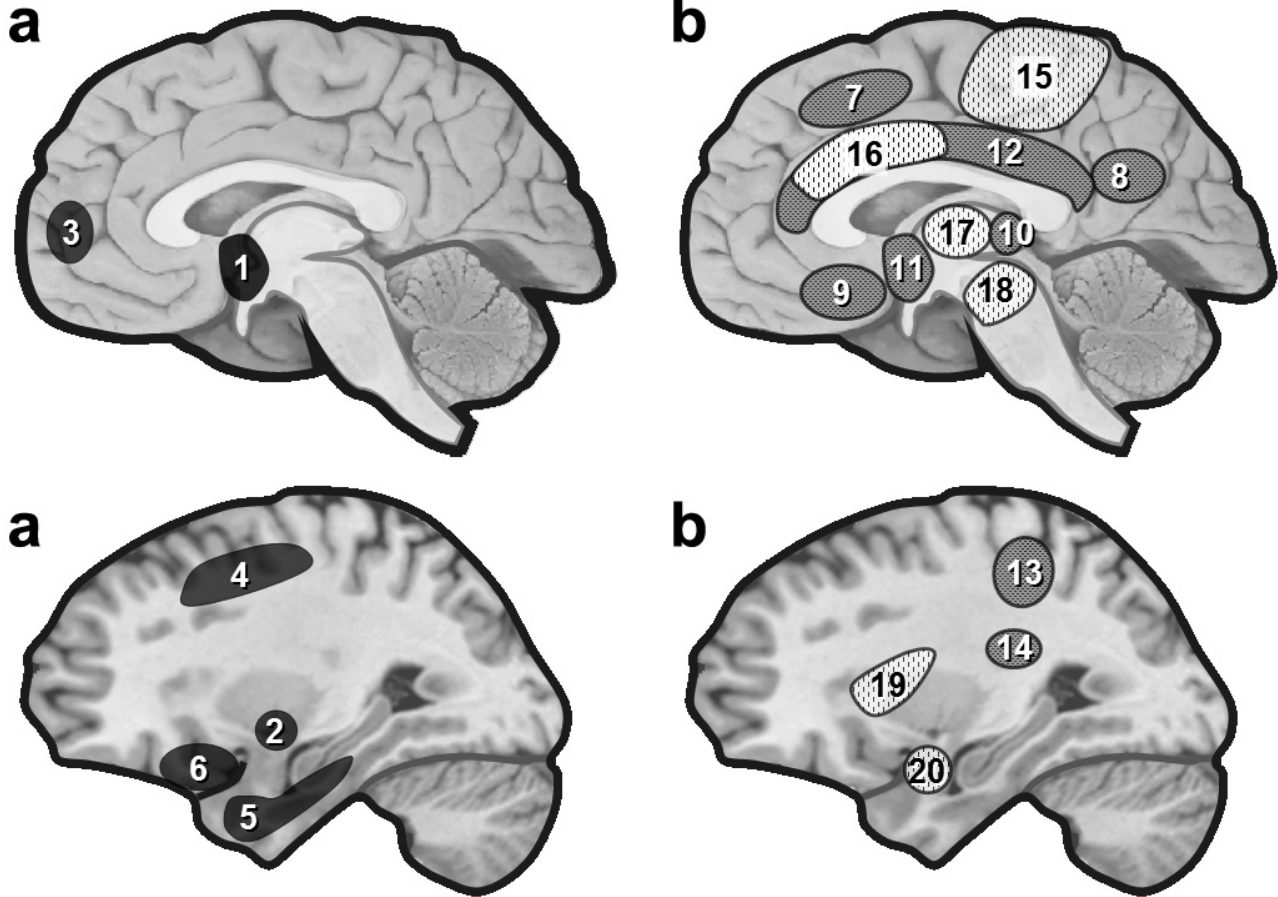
(a) Anatomical brain changes in narcoleptic patients assessed by VBM. In narcoleptic patients, cortical gray matter loss was found to affect frontal brain regions,³⁷ temporal regions,³⁸ as well as hypothalamus, cerebellum (vermis) and ventral striatum³⁹ (see also⁴⁰). However, hypothalamus damage is not systematically found in VBM studies.³⁶ (b) Functional brain changes in narcolepsy. Narcoleptic patients show reduced baseline activity during wakefulness (¹⁸FDG PET, SPECT) in several regions including the hypothalamus and mediodorsal thalamic nuclei.^{45,46} During cataplexy, one SPECT study reported hyperperfusion in several brain regions including limbic area, brainstem and motor regions⁵¹ (but see also⁵²). 1 = hypothalamus, 2 = nucleus accumbens (right), 3 = frontomesial, 4 = prefrontal (right), 5 = inferior temporal, 6 = inferior frontal, 7 = superior frontal, 8 = inferior parietal lobule, 9 = rectal/subcallosal gyrus, 10 = dorsal thalamus, 11 = hypothalamus, 12 = cingulate, 13 = post central/supramarginal, 14 = caudate, 15 = premotor and motor cortex, 16 = cingulate, 17 = thalamus, 18 = brainstem, 19 = insula (right), 20 = amygdala (right).
